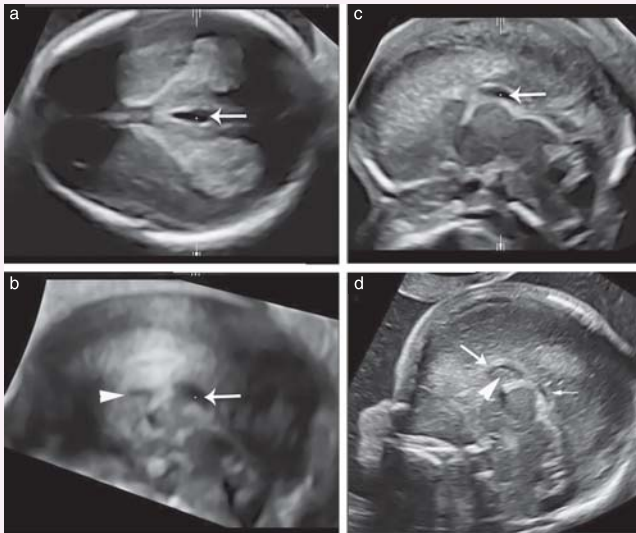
(a–c) Neurosonography at 15 gestational weeks. (a) In axial transventricular plane, oval anechogenic structure (arrow) is evident along midline. (b) Corresponding midsagittal plane reconstructed from (a), demonstrating that, due to its position, this structure is cavum veli interpositi (CVI) (arrow). Initial bud of corpus callosum is also evident in this plane (arrowhead). (c) Two-dimensional image in midsagittal view of same fetus, showing same findings as in (b), but with higher resolution. (d) At 16 gestational weeks, initial bud of corpus callosum (large arrow) and small cavum septi pellucidi (arrowhead) can be demonstrated on high-frequency transvaginal ultrasound. Regression of CVI can also be seen (small arrow).
